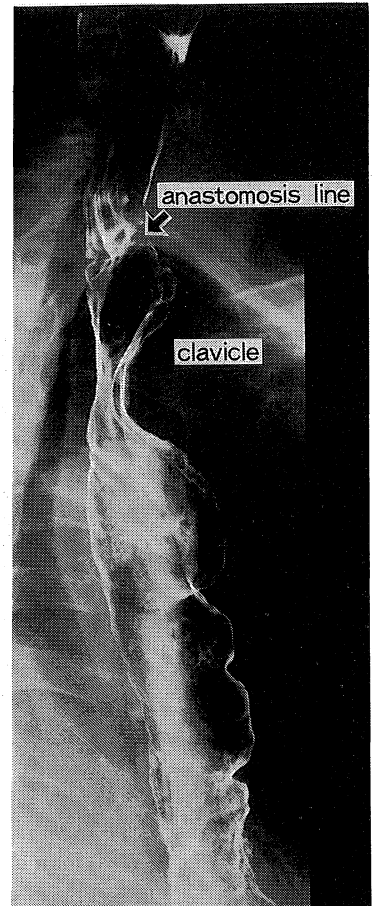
Postoperative X-ray picture (anastomotic portion).
